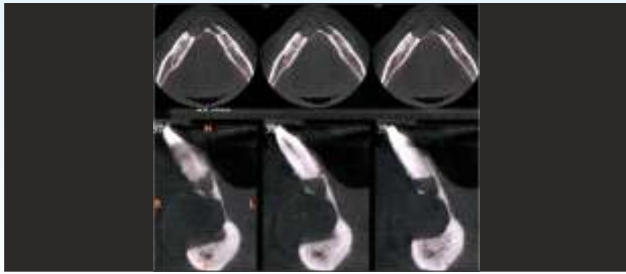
Axial section and oblique coronal section of CBCT showing well-defined hypo-density with labial plate perforation.
